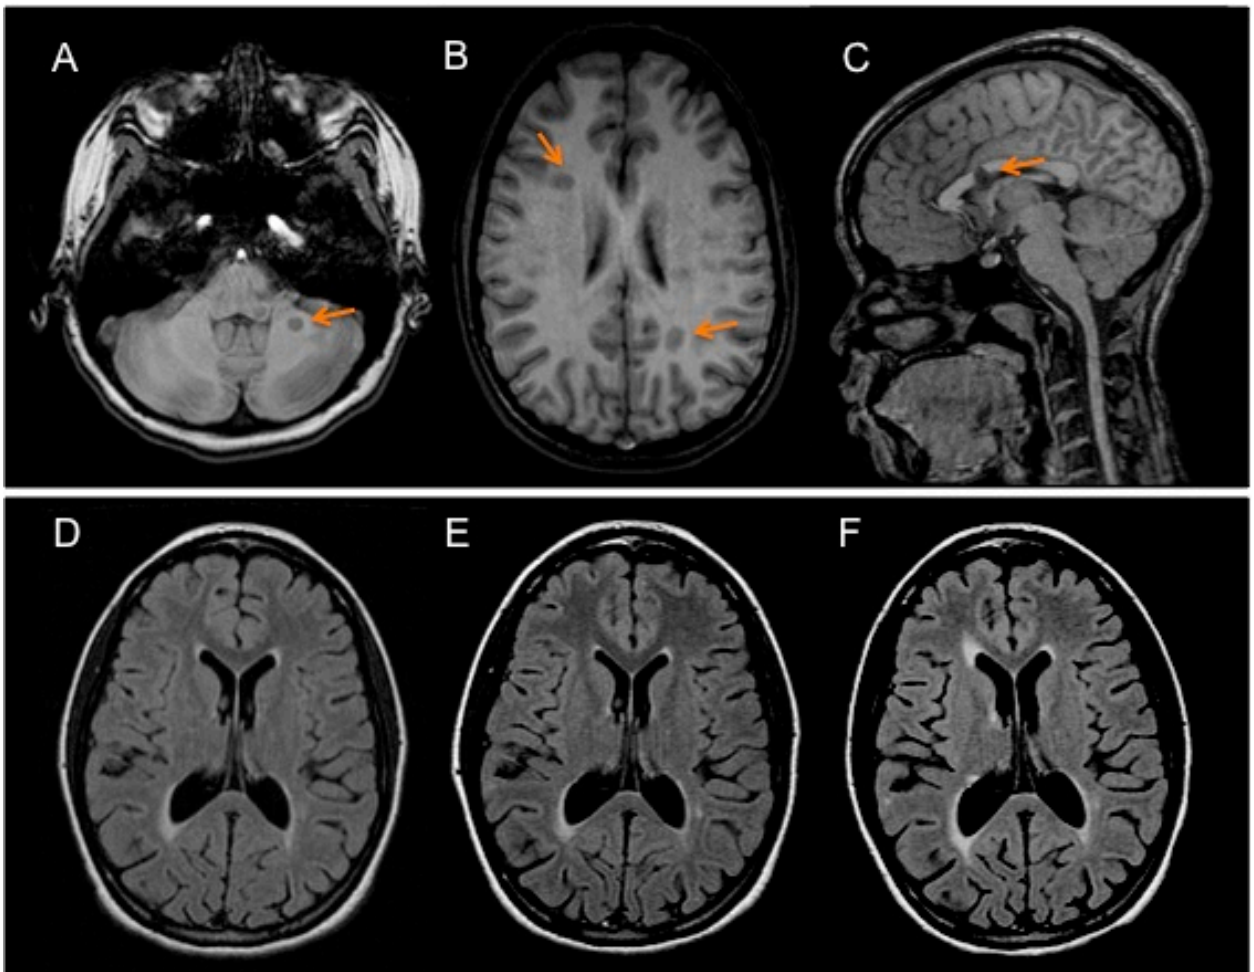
“Black holes” and progressive brain volume loss in children with MS. (A-C) T1-weighted images of three children with MS showing T1 hypointense lesions (arrows) in the cerebellar (A) and cerebral (B) white matter and in the corpus callosum (C). (D-F) Serial FLAIR images from a child with MS acquired 4.9 years (D), 5.9 years (E) and 8.4 years (F) from onset; evidence of brain volume loss is depicted by enlargement of the lateral ventricles and widening of the sulci over time.
